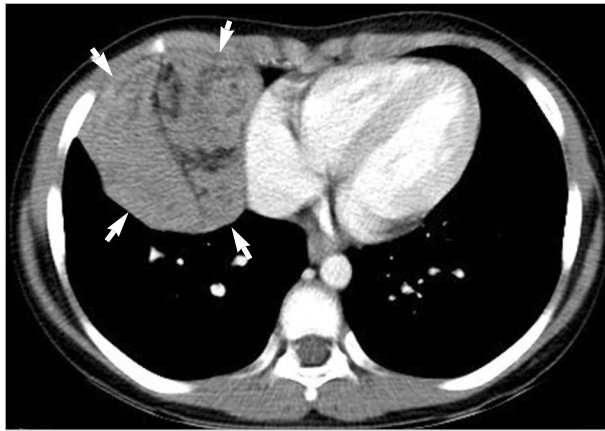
Chest computed tomography shows a well-demarcated huge ovoid soft tissue mass (arrows) with fatty attenuation.
